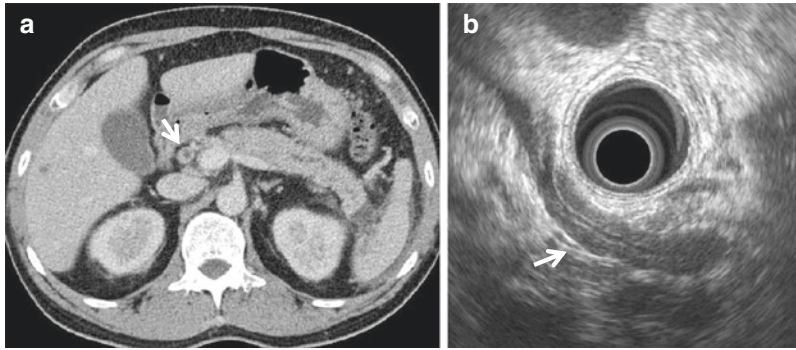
A case of IgG4-SC with no biliary stricture but severe thickening of the bile duct wall [11]. Contrast-enhanced computed tomography revealed diffuse swelling of the pancreatic body and tail with a capsule like a low-density rim around the edge of the lesion and wall thickening with contrast enhancement in the region from
